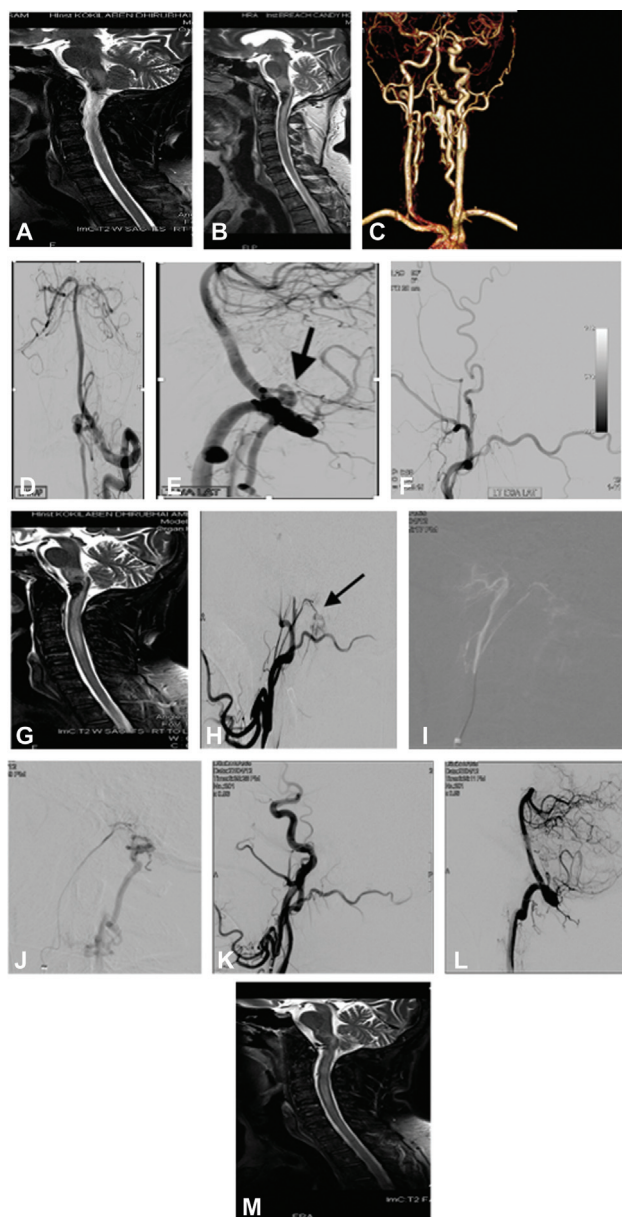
MRI T2 (A) showing abnormal vascular lesion at the level of the anterior foramen magnum with mild edema of the medulla and cervical cord. Follow up MRI (B) at 1 week showing premedullary haemorrhage with increased medullary and cervical cord edema. 3D CTA (C) showing AF fistula. (D) Left VA run showing a DAVF fed by the meningeal branches of both intra and extradural portion of left VA and a small branch from anterior spinal artery (arrow). Lat VA run showing venous aneurysm (arrow in E) Normal ECA run (F). Repeat MRI showing significantly increased cord edema (G). ECA angiogram (H) showing newly developed feeders from meningeal trunk of APhA. SS cannulation of right APhA meningeal trunk (I). SS run showing filling of fistula (J). Post ECA run (K) showing complete occlusion of the fistula. Post VA run showing no filling of fistula from VA branches (L). MRI on fourth day showing significant reduction in cord edema (M).
